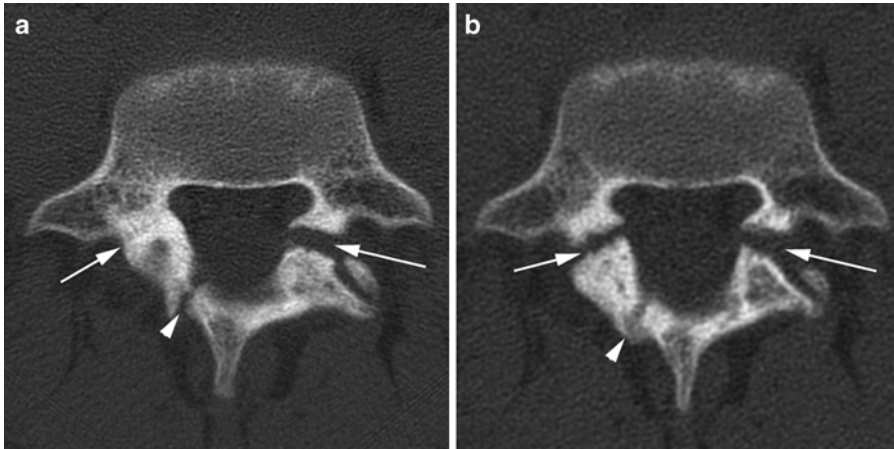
Bilateral spondylolysis with laminolysis. (a) Example of a 15-year-old young male athlete with several months of worsening low back pain. His CT at initial presentation demonstrated evidence of early right and terminal
